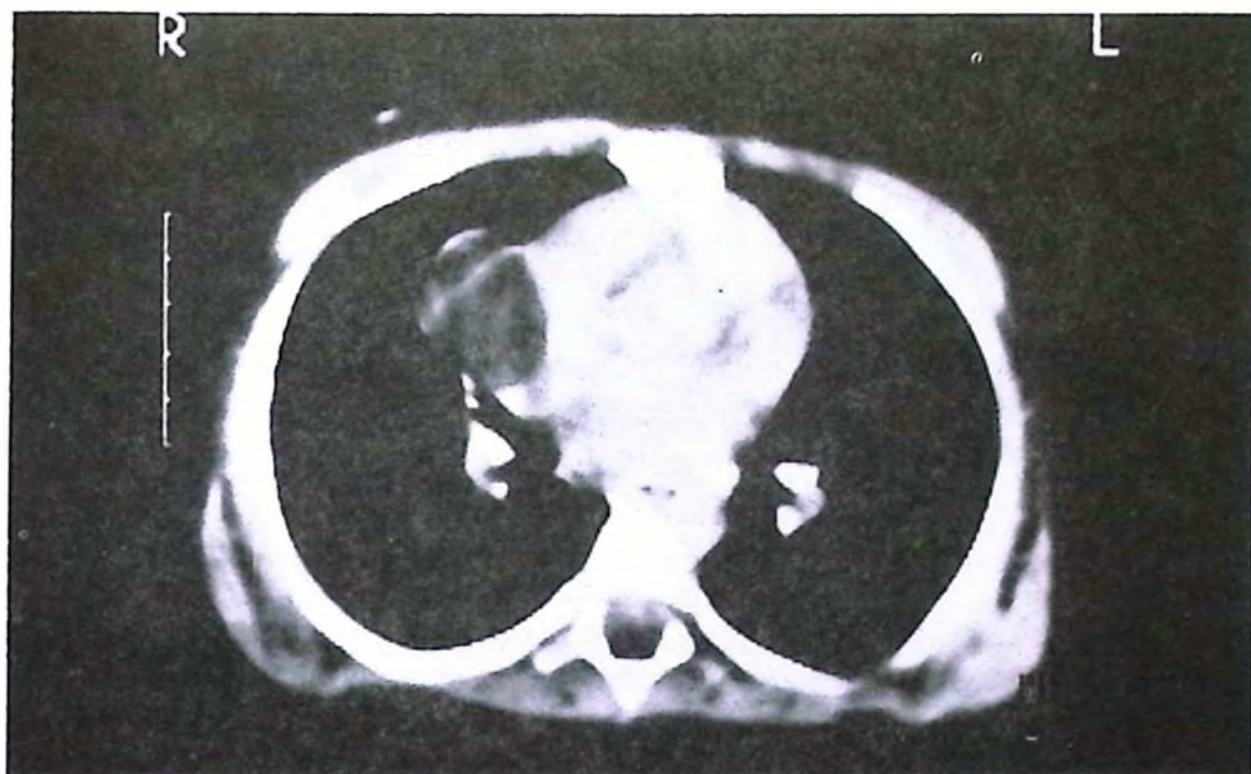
Thoracic CT revealing presence of a cyst.
